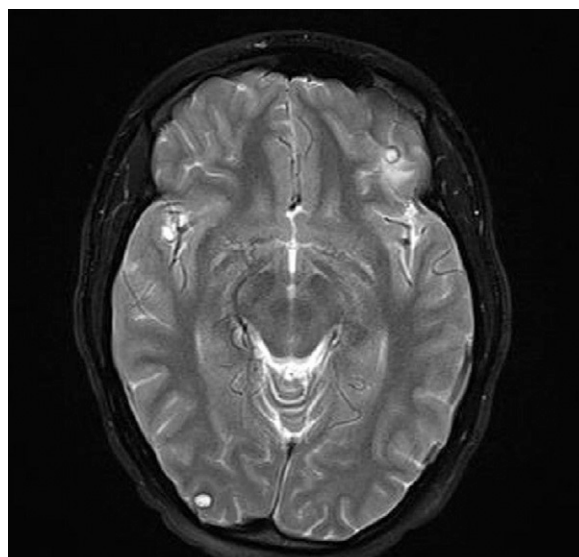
Magnetic resonance imaging of the brain with contrast. There is a 5-mm peripherally enhancing lesion with surrounding vasogenic edema in the left inferolateral frontal lobe, likely representing a colloidal vesicular neurocysticercosis lesion. An additional nonenhancing lesion with similar signal characteristics in the right occipital lobe is present, matching the area of calcification on a previous computed tomographic scan.
